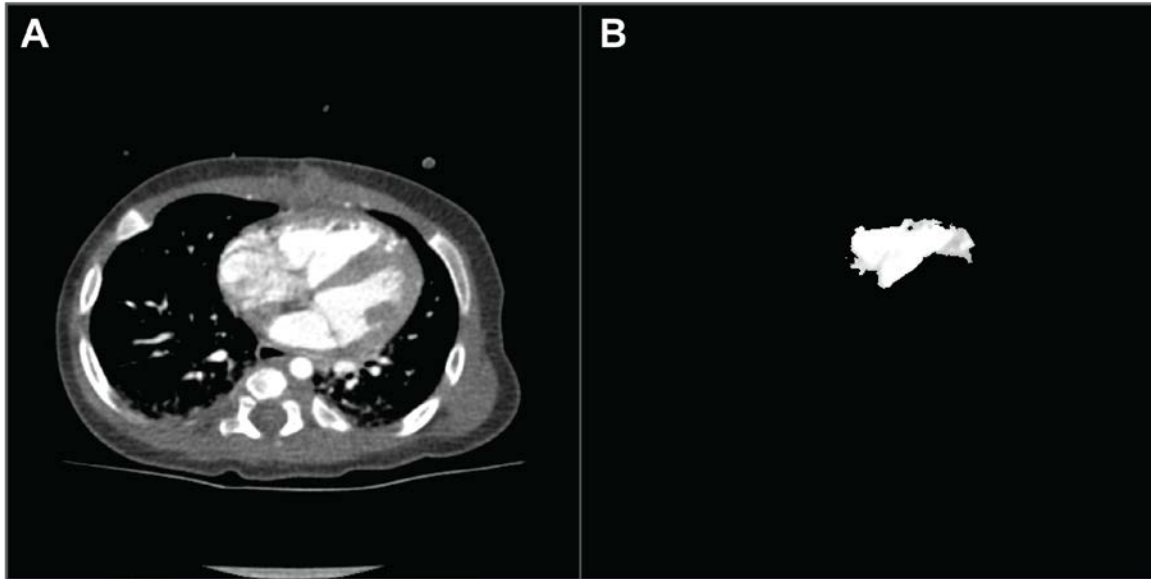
Contrast-enhanced CT scan. B) Masked subset from CT scan. The mask is of the right ventricle.
